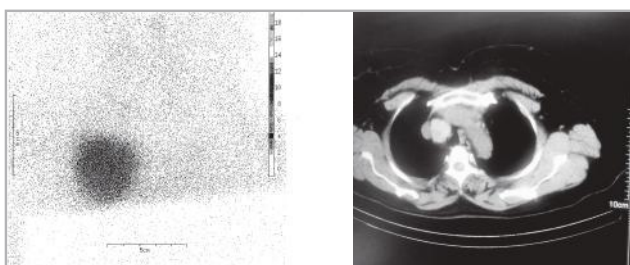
(A) $^{99m}\text{TcO}_4$ thyroid scintigraphy showing increased radiotracer concentration at the site of lesion in right superior mediastinum and no significant uptake in the neck. (B) CT scan of neck and chest confirmed the presence of a mass (3.1 X 2.9 cm) in the superior mediastinum.
